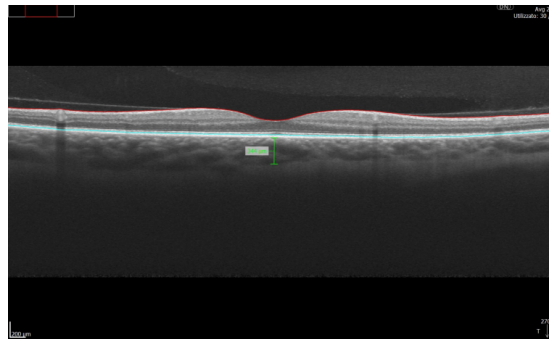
1 Example of Manual CT Measurement from the Bruch's membrane to the Chorio-Scleral Interface on 4 times magnified Vertical OCT B-scan
